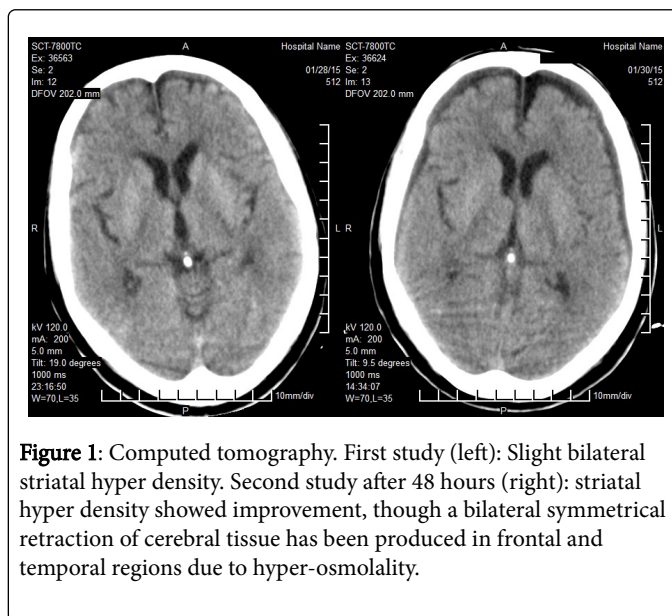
Computed tomography. First study (left): Slight bilateral striatal hyper density. Second study after 48 hours (right): striatal hyper density showed improvement, though a bilateral symmetrical retraction of cerebral tissue has been produced in frontal and temporal regions due to hyper-osmolality.
